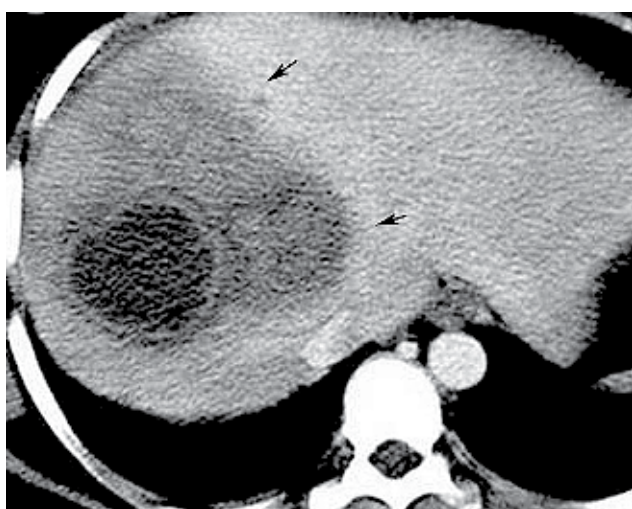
Hepatic abscess and adjacent hyperemia. enhanced helical CT: high-attenuation area around the abscess.
